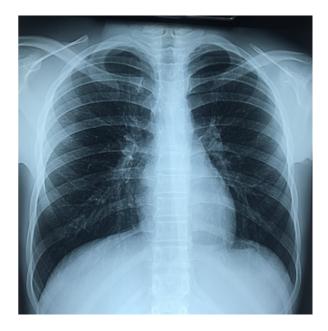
Chest x-ray showing no bony deformity.
